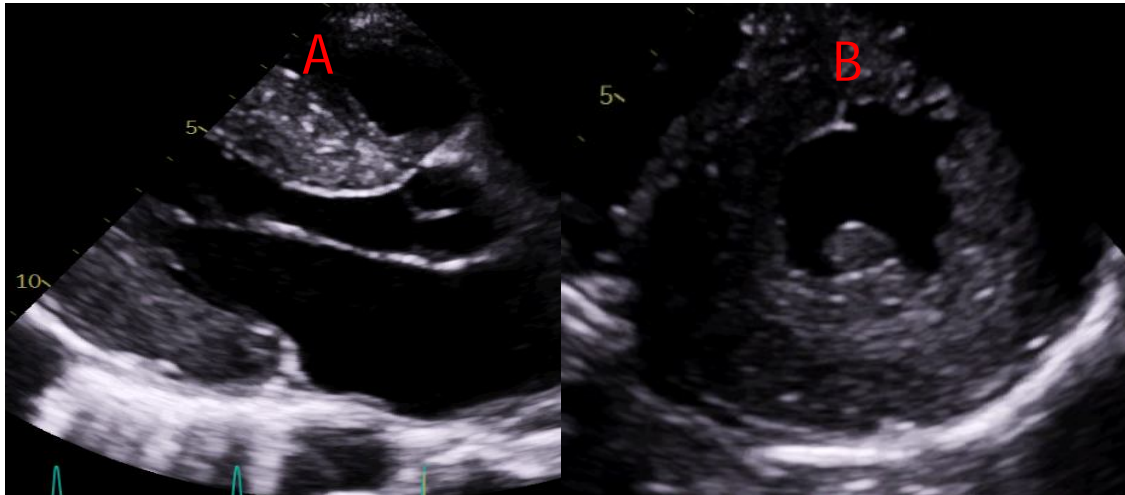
TTE: A- Parasternal long axis view showing hypertrophy of the left ventricular with a septum measuring 15mm. B-Short axis view showing a global hypertrophy of the left ventricle.
